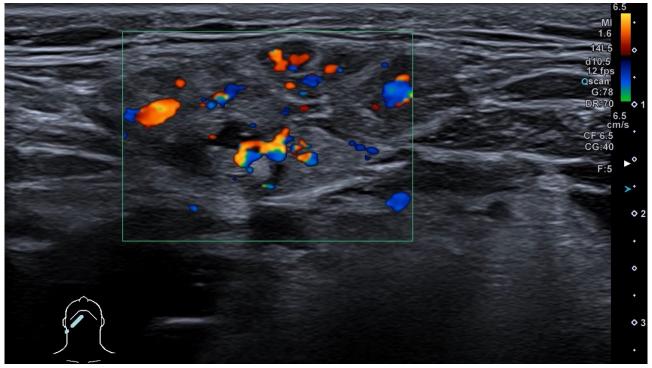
Color doppler ultrasonographic image of increased blood flow (hypervascularisation) in the salivary gland in the setting of inflammation.
